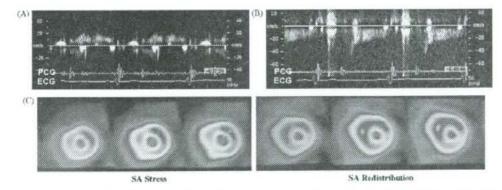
Thirty-year-old male with a history of syncope and chest discomfort. Transthoracic Doppler echocardiographic measurement of left anterior descending coronary artery (A) and intramyocardial coronary artery (B). The pulsed Doppler echocardiography in the intramyocardial coronary artery demonstrating characteristic no reflow-like pattern, so we classified this patient into group B. (C) Thallium-201 scintigraphy showing abnormal perfusion with reversible ischemia in the anteroseptal segments.
